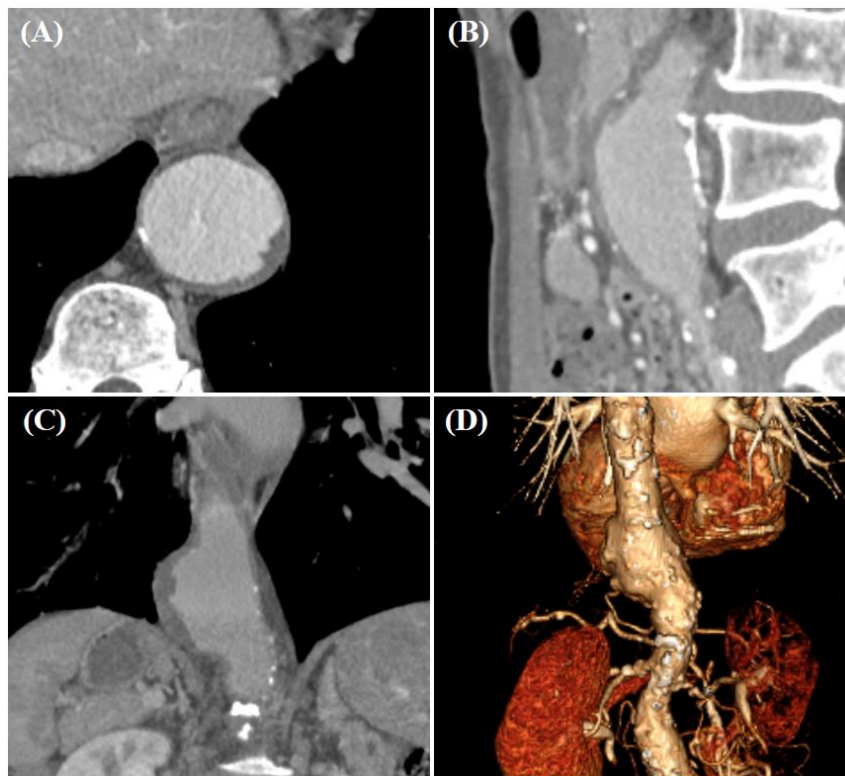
CTA imaging of an AAA: (A) Axial view; (B) Sagittal view; (C) Coronal view; (D) 3D rendering. The aortic lumen is contrast-enhanced while the intensities of intraluminal thrombus and aortic wall are similar without a clear border.
